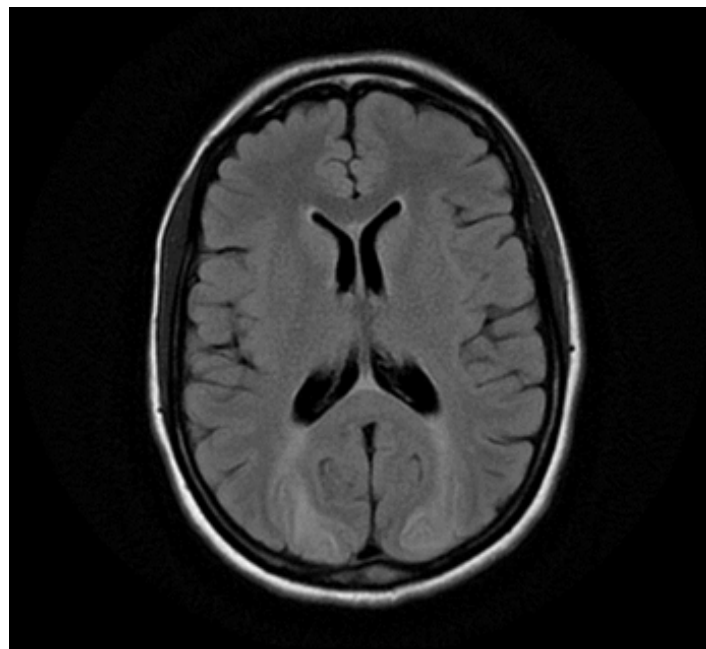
Magnetic resonance imaging scan showing symmetrical areas of increased signal in the occipital lobes (T2 and FLAIR sequences).
